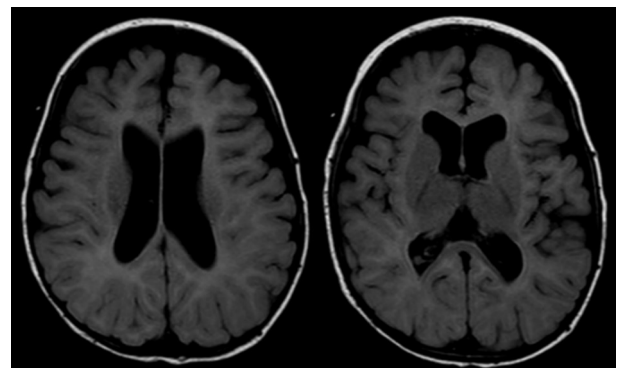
The patient's brain magnetic resonance image. There is no specific brain anomaly on brain magnetic resonance T2-weighted and fluid attenuated inversion recovery axial image at 7 months old.
